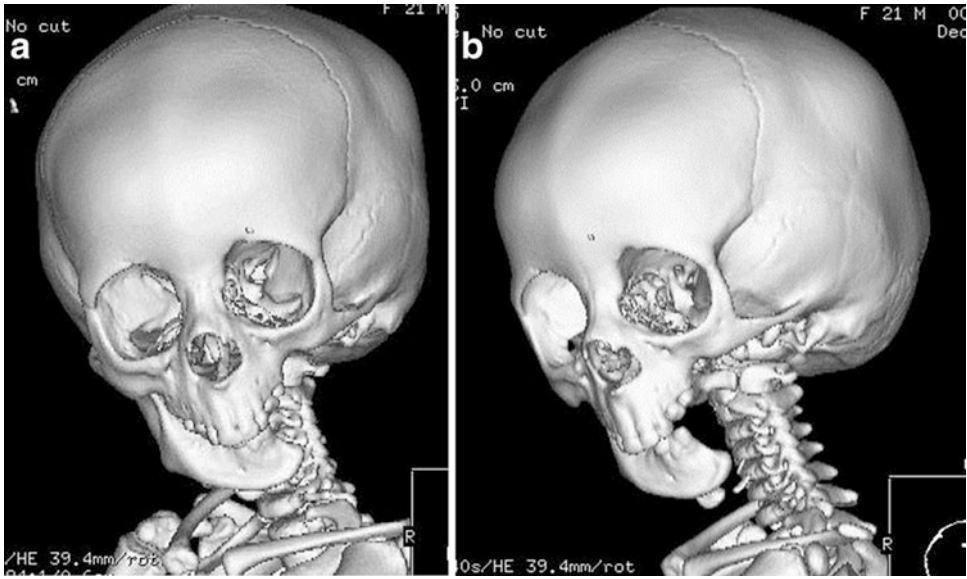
(a, b) CT of the face (AP and lateral views) show left hemimandibular agenesis (complete absence of the body, angle, ramus, and condyle) and a significant aplasia of posterior maxilla on the *left*
